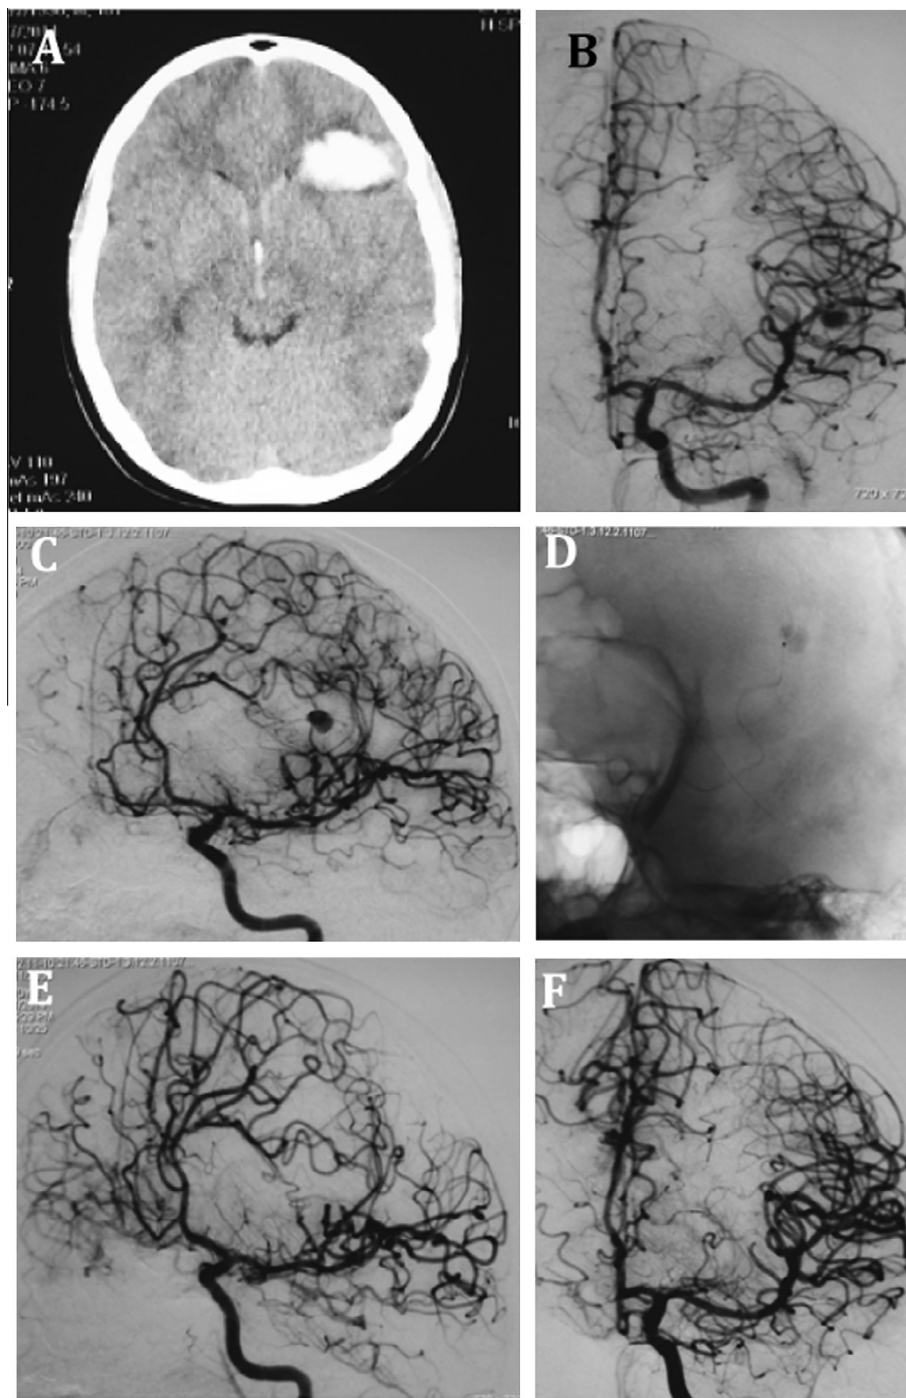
(A) CT showing intracerebral and intraventricular bleeding secondary to rupture mycotic aneurysm. (B and C) Showing mycotic aneurysm along the left MCA branches. (D) Selective closure of the aneurysm and parent artery by Cyanoacrylate/Lipiodol mixture. (E and F) Final control showing closure of the aneurysm and MCA branch.
